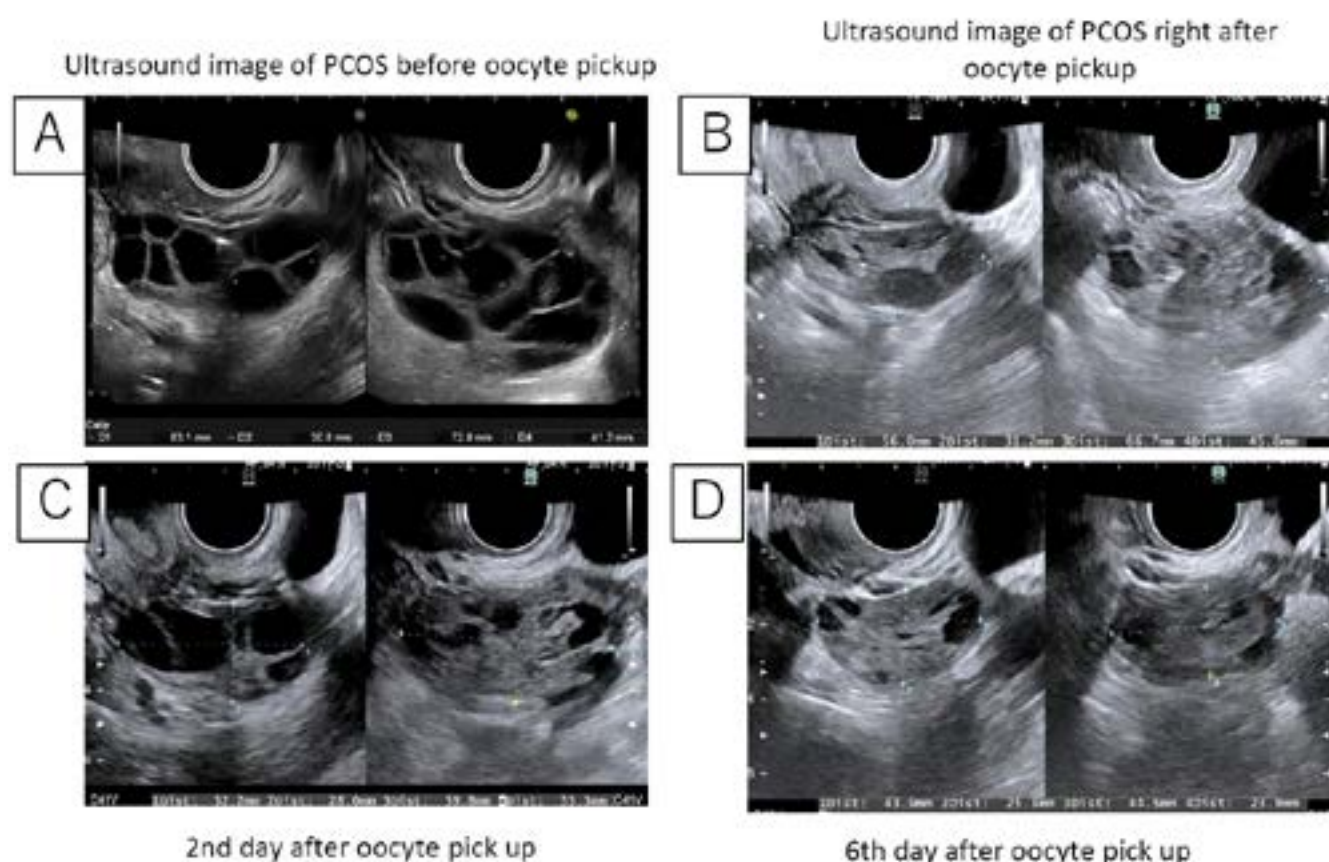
Ultrasound image of bilateral ovaries in successful case using new treatment and Ultrasound image of echo free space in Douglas' pouch in successful case using new treatment.
